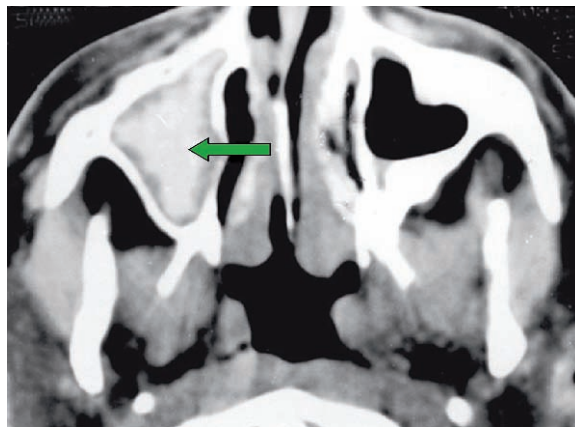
Cropped axial CT scan showing *Aspergillus* sinusitis (arrow)
